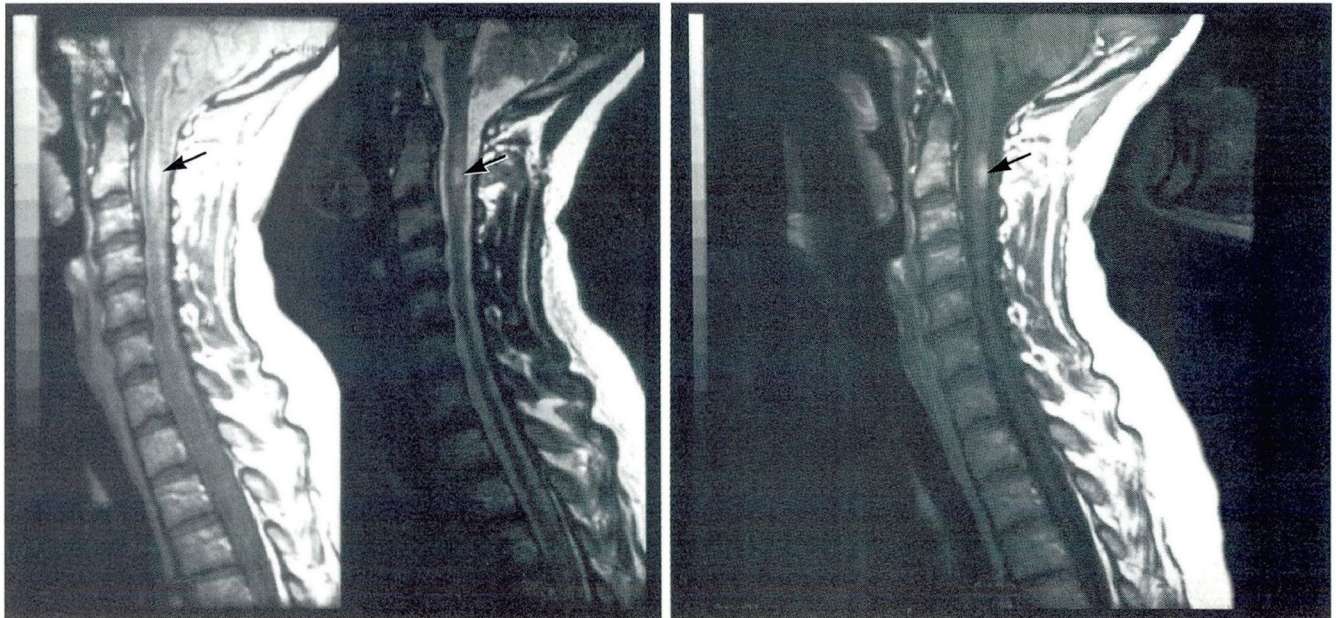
Left, T2-weighted sagittal magnetic resonance image of the cervical spinal cord showing an intramedullary, ovoid area of increased signal adjacent to the C2 vertebral body (arrow), predominately involving the posterior aspect of the cord and associated with mild cord swelling. Right, T1-weighted sagittal image following the administration of gadolinium, showing diffuse enhancement of the posterior aspect of the same lesion (arrow).
